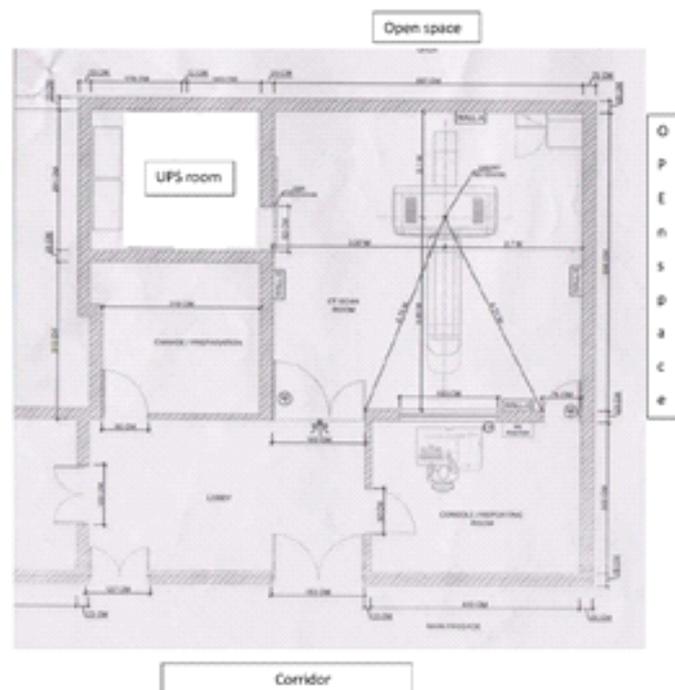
shows that CT scanner position, console and space around CT room and their shielding thickness around the CT room.
